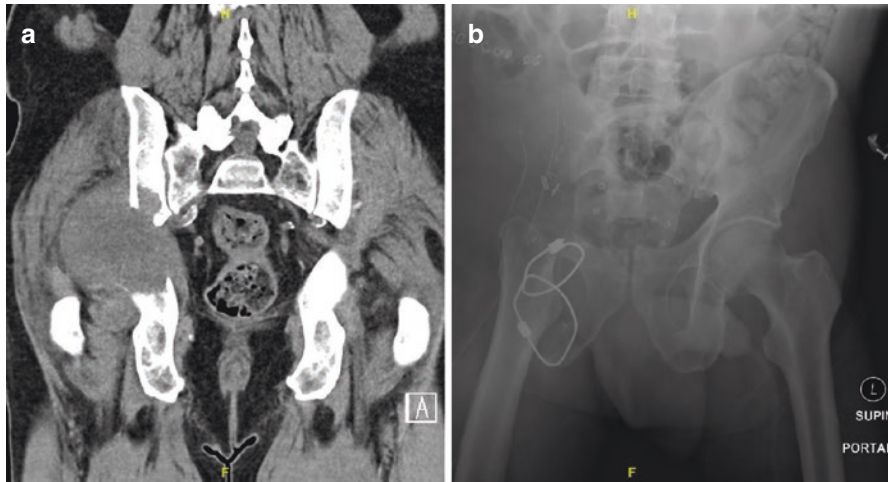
(a) Coronal CT scan demonstrating large periacetabular sarcoma. (b) Type I-II-IV resection followed by ischio-femoral pseudarthrosis reinforced by two cables
